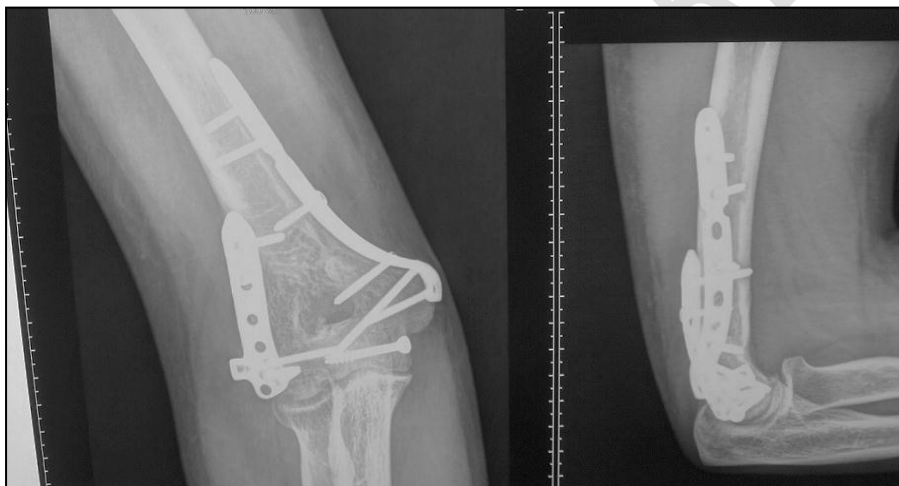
Case 1- 39 years old male. MBA.RT distal humeral fracture. Fracture pattern: C2. Associated fractures: none. Time till surgery: 4 days. Approach: triceps reflecting, follow up X-rays at 24 months. complete union. ROM: flexion-extension 5°-120°. MEPS 100
